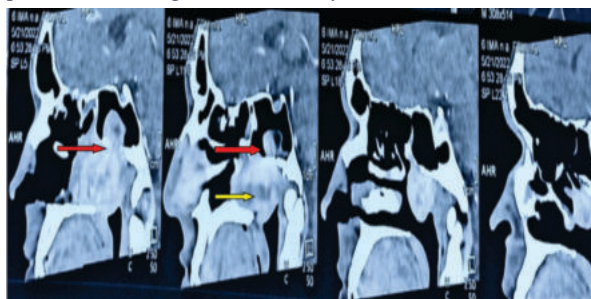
CT Scan of paranasal sinus with Sagittal view : Yellow arrow showing the mass(Juvenile nasopharyngeal angiofibroma) and Red arrow showing extension of mass into sphenoidal sinus respectively.
